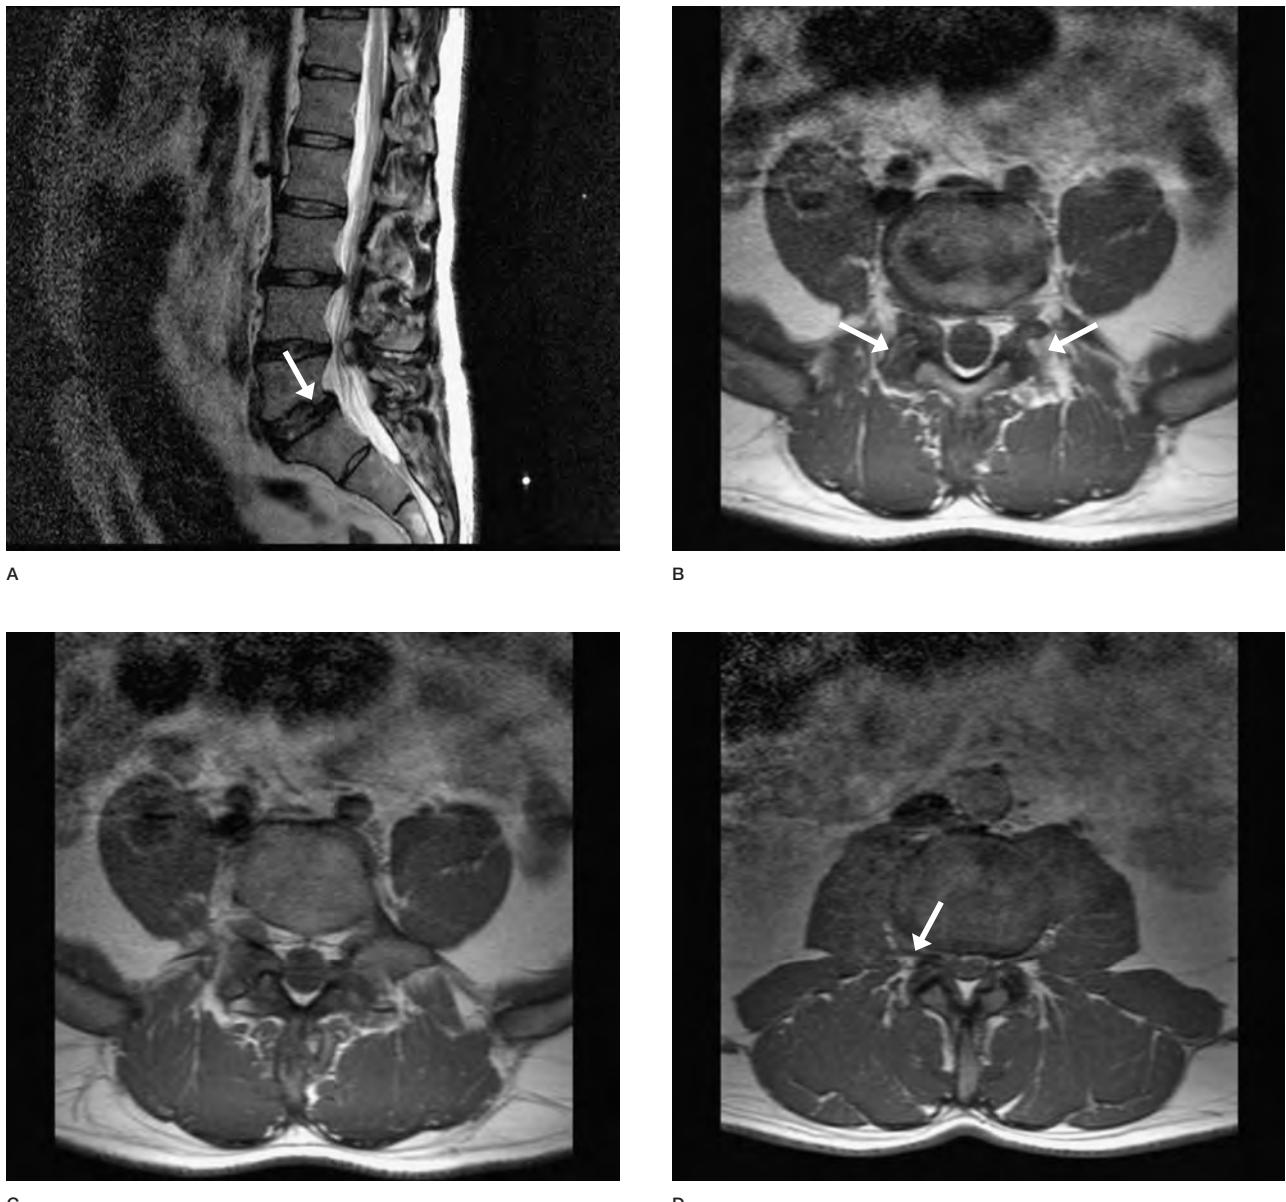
A 66-year-old man with chronic low back pain complicated by right sciatic nerve pain. MR scan (A-C) depicts spondylolisthesis of L5 over S1 (arrows) associated with degenerative arthrosis of the facet joints. Circumferential protrusion of the L3-L4 disc is also present mainly in the right intra-extraforaminal region (arrow) (D). The patient underwent O_2-O_3 treatment with CT-guided intraforaminal infiltration into both L3-L4 (right monolateral) and L5-S1 (bilateral) followed by 4 outpatient treatments with paravertebral intramuscular injections into the two levels. At 1 year follow-up the patient referred an excellent resolution of clinical symptoms (assessed by our modified McNaib method).
